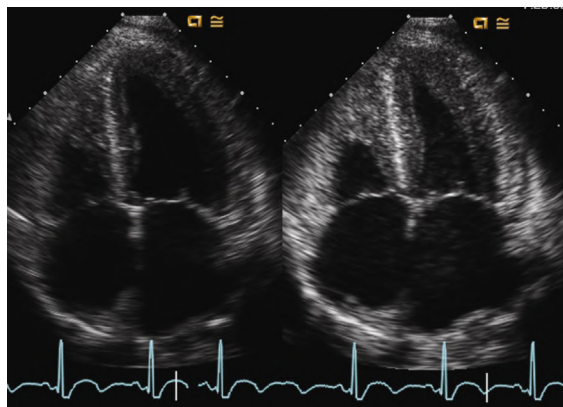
Harmonic imaging compared with fundamental frequency imaging. Harmonic imaging improves identification of the LV endocardial border, as seen in this apical 4-chamber view recorded with a 4-MHz transducer using (*left*) fundamental frequency imaging and (*right*) harmonic imaging.
